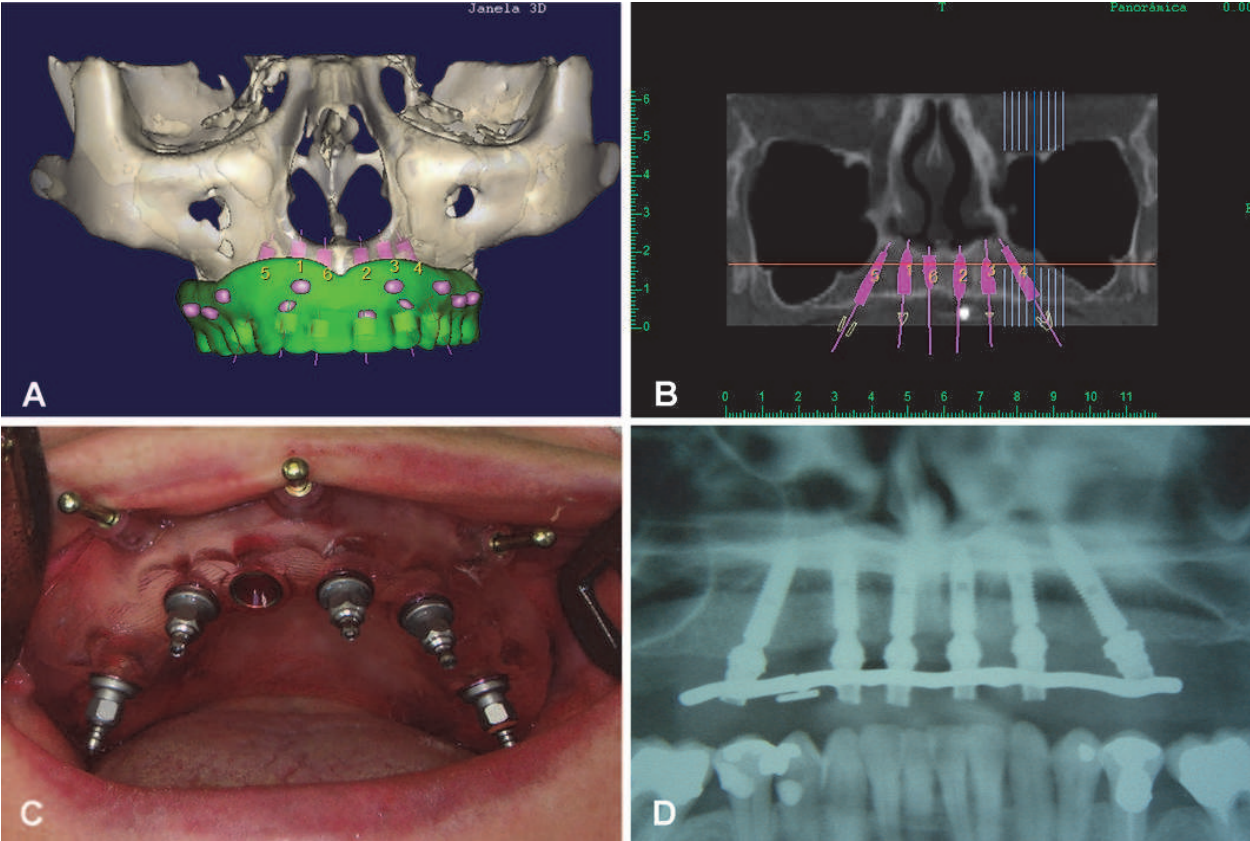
Guided surgery for complete upper arch rehabilitation. a) Three-dimensional view of preoperative planning. Note radiopaque markers used to superimpose scans of the guide (isolated and in occlusion). Dentaslice® software package (Bioparts®, Brazil). b) Preoperative implant positioning. c) Five implants in place. Note insertion of anchor pins into stereolithographic guide. Neoguide® system (Neodent®, Brazil). d) Postoperative panoramic radiograph. Note similarity to virtual planning.
